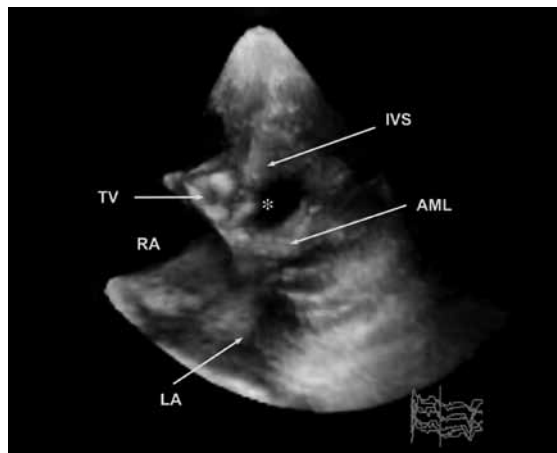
Example of transthoracic RT3DE representation of a large membranous VSD (*) in a non-operated 61-year-old woman with Eisenmenger's syndrome and severe right heart dilatation. TV tricuspid valve, RA right atrium, IVS interventricular septum, AML anterior mitral leaflet, LA left atrium.
